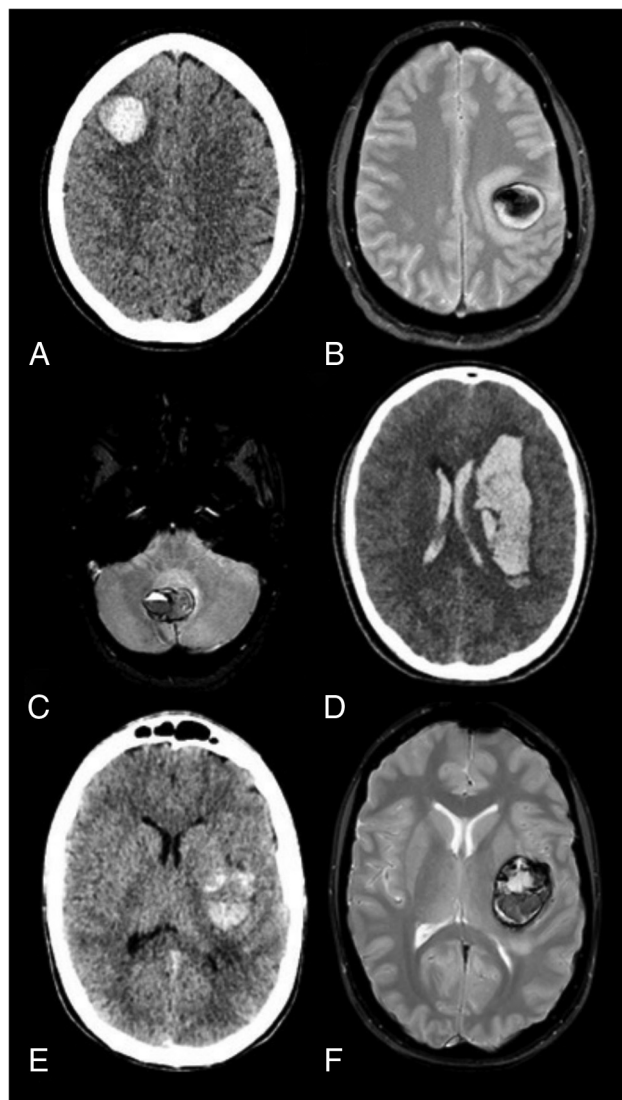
Assessment of hematoma shape. A, Spherical, acute lobar hematoma on plain CT of a patient with a pathologically proved hemorrhagic cerebral cavernoma. B, Spherical lobar hematoma on T2*-weighted imaging in a patient with pathologically proved hemorrhagic cerebral cavernoma. C, Ovoid cerebellar hematoma on T2*-weighted imaging of a patient with pathologically proved hemorrhagic cavernoma. D, Plain CT obtained at admission in a patient with an angiographically proved cerebral AVM. The elongated shape of the hematoma did not fulfill the criteria spherical or ovoid. Its margins were considered irregular because angular aspects were present. It was associated with intraventricular hemorrhage. E and F, Hemorrhagic cerebral cavernoma. Both plain CT (D) and T2* MR images (E) were available to assess the hematoma shape. The hematoma shape was classified as spherical/ovoid on the basis of MR imaging.
